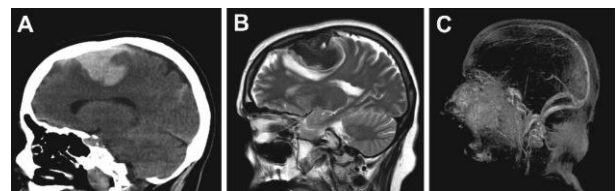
Case of atypical bleeding; a- Sagittal CT, b- Sagittal T2-weighted MRI, c- Complete suppression of the bleeding is seen as there is no contrasting in 3D angio window.
